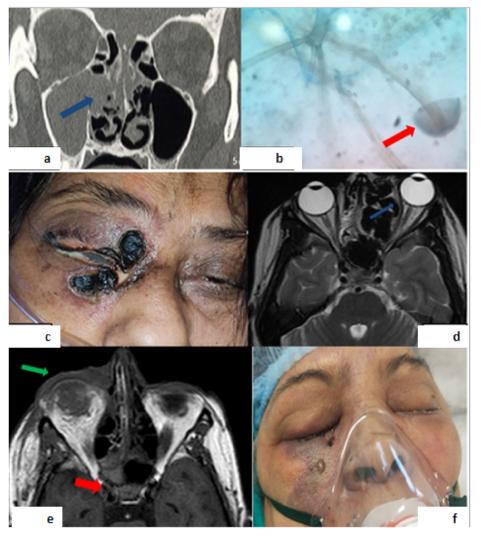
Fig. 1a. CT scan showing mucoperiosteal thickening in bilateral maxillary, ethmoid, left frontal sinuses, and blocked right osteomeatal opening (blue arrow). Fig. 1b. Lactophenol cotton blue mount of nasal discharge showing broad aseptate hyphae with sporangiospore (red arrow) of rhizopus. Fig. 1c. Image of Case 3 showing right periorbital swelling, black patch on right lids. Fig. 1d. T2W MRI showing hypointense lesion causing expansion of nasal cavity, erosion of ethmoid sinus and medial wall of left orbit (blue arrow) causing mass effect on left medial rectus muscle and proptosis of left eye ball. Fig. 1e. Mild proptosis (green arrow), pre-orbital soft tissue swelling and altered shape of right orbit, thickening and peri-neural fat stranding of right optic nerve, and bulky right cavernous sinus (red arrow) suggestive of right pre and post septal orbital cellulitis, endo-ophthalmitis, and right cavernous thrombosis. Fig. 1f. Image of Case 5 showing bilateral facial and eve (right > left) swelling with necrosis of surrounding skin.
